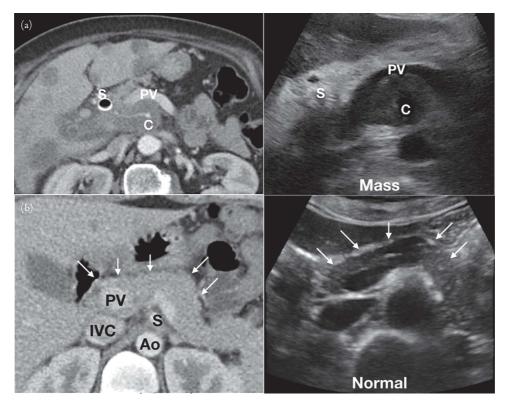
(a) Pancreatic head mass on computed tomography (CT) and ultrasound (US). The top panel shows an axial CT plane while the bottom panel shows the representative US plane of this patient with pancreatic cancer. The pancreatic mass encases the portal vein (PV) as well as the celiac trunk (C). There is a biliary stent that has been placed (S) for management of the patient's obstructive jaundice. Note also the many liver metastases on CT. (b) Identification of the pancreas. The left panel shows a computed tomography (CT) axial cut of normal hepatobiliary anatomy, while the right shows a representative ultrasound image. The pancreas (arrows) lies just anterior to where the portal vein forms from the mesenteric veins and the splenic vein (PV). The pancreatic head lies anterior to the inferior vena cava, while the tail surrounds the aorta (Ao). The superior mesenteric artery (S) lies just posterior to the pancreatic body. Knowing the relative vascular anatomy allows the sonographer to identify the pancreas, which can be difficult as it is usually iso-echoic with the liver.
